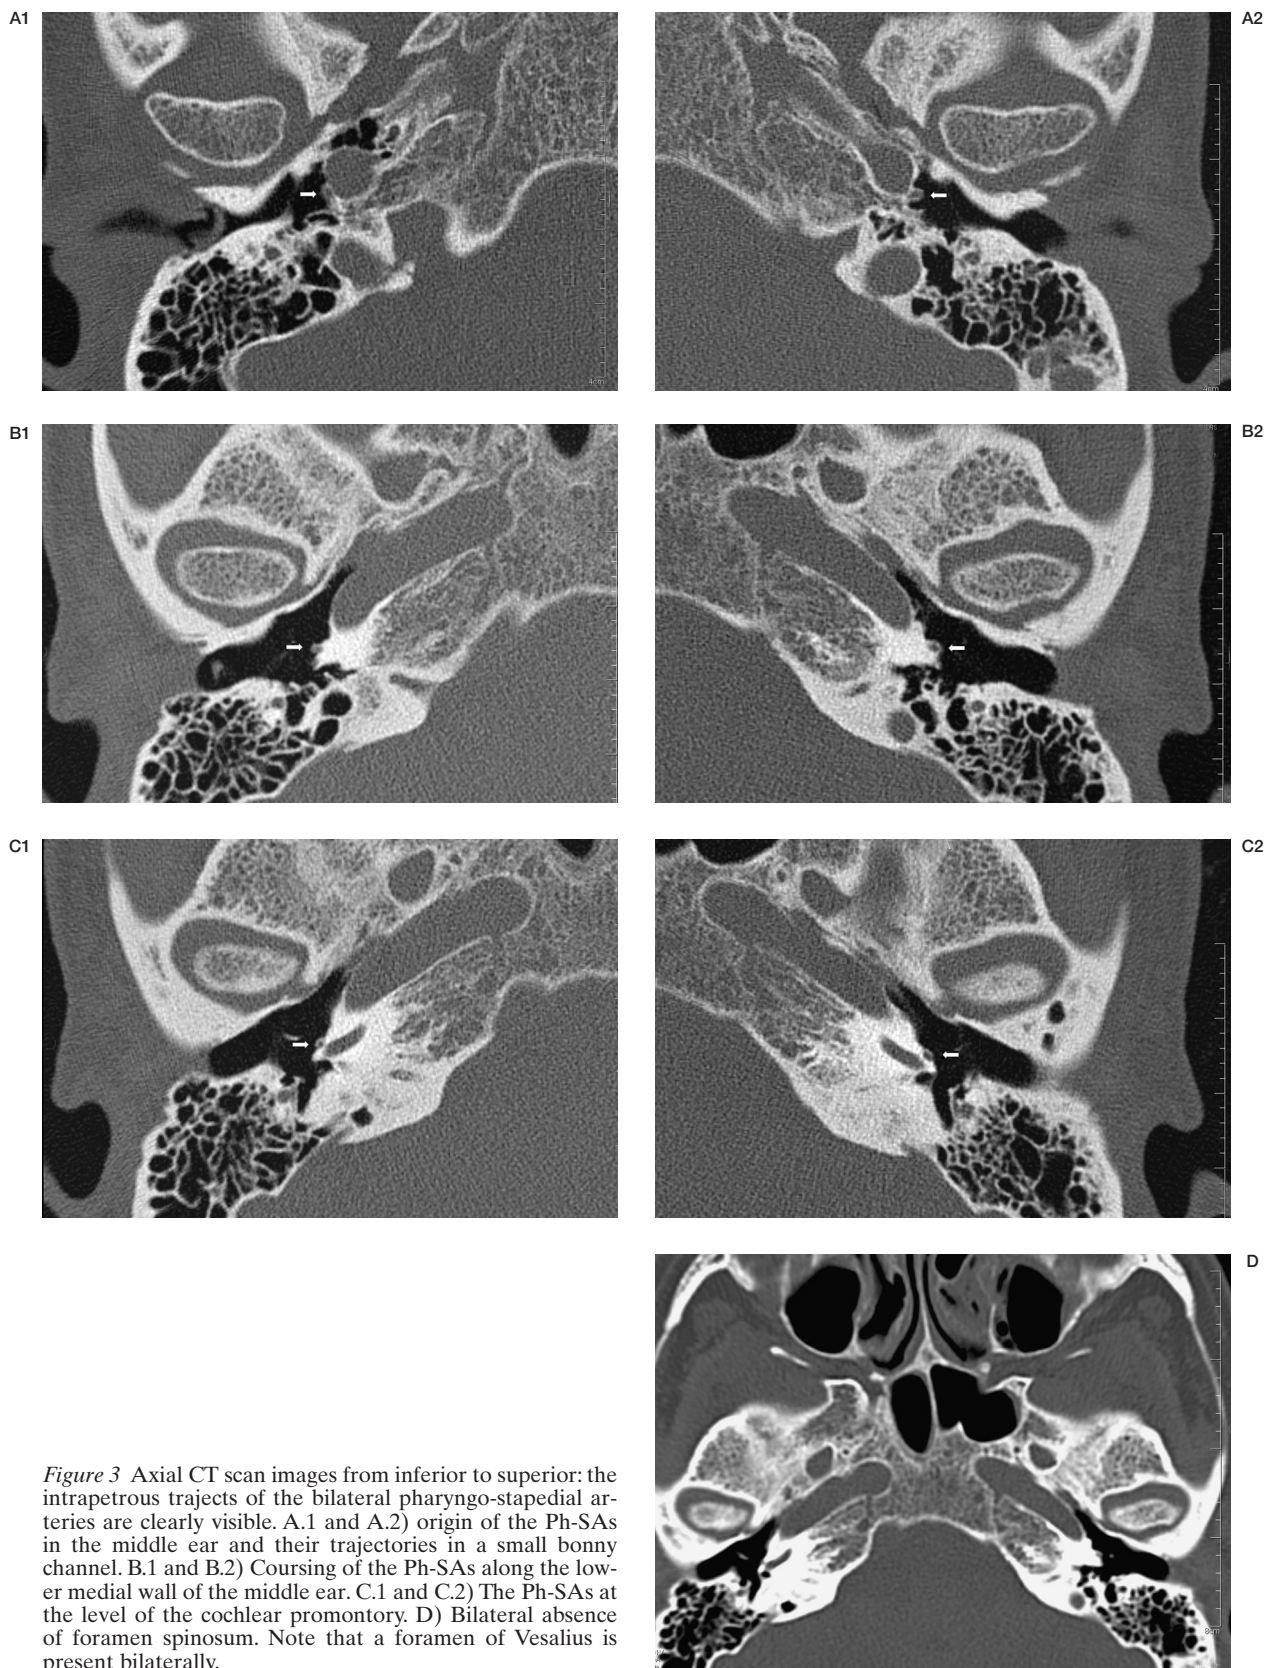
Axial CT scan images from inferior to superior: the intrapetrous tracts of the bilateral pharyngo-stapedial arteries are clearly visible. A.1 and A.2) origin of the Ph-SAs in the middle ear and their trajectories in a small bonny channel. B.1 and B.2) Coursing of the Ph-SAs along the lower medial wall of the middle ear. C.1 and C.2) The Ph-SAs at the level of the cochlear promontory. D) Bilateral absence of foramen spinosum. Note that a foramen of Vesalius is present bilaterally.
